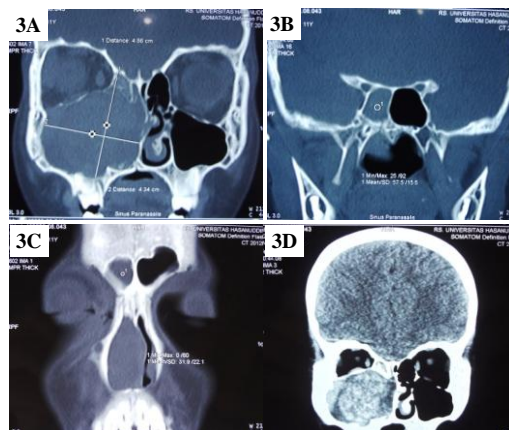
Paranasal Sinus CT Scan without contrast with coronal section. A) Tumours in from the right maxillary sinus compressed the right ethmoidal sinus and pushed nasal septum to the left. The tumour also destroyed the lateral wall of the right maxillary sinus; B) The tumour infiltrated the right sphenoid sinus; C) The tumour also infiltrated the right frontal sinus; D) Head CT coronal section without contrast, the nasal septum was pushed to the left, and the tumour infiltrated the ethmoidal sinus and right sphenoid sinus
